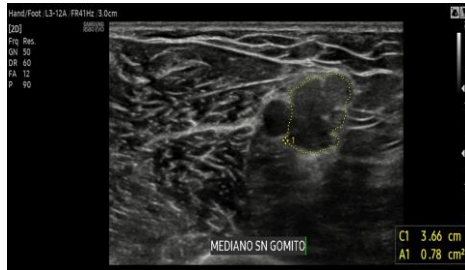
Ultrasound evaluation of the left median nerve showed an increase in Cross-Sectional Area (CSA).
